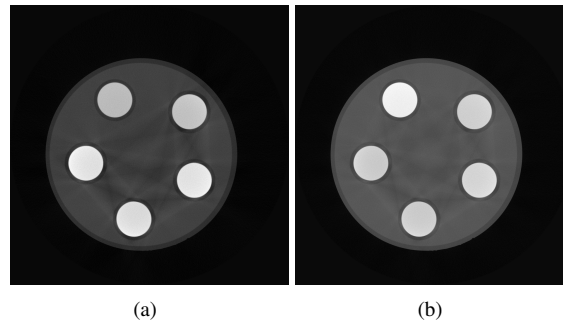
Reconstructed CT slice of the scans performed at 50 kV using 3 mm Al (a) and at 100 kV using 3 mm Al (b)
